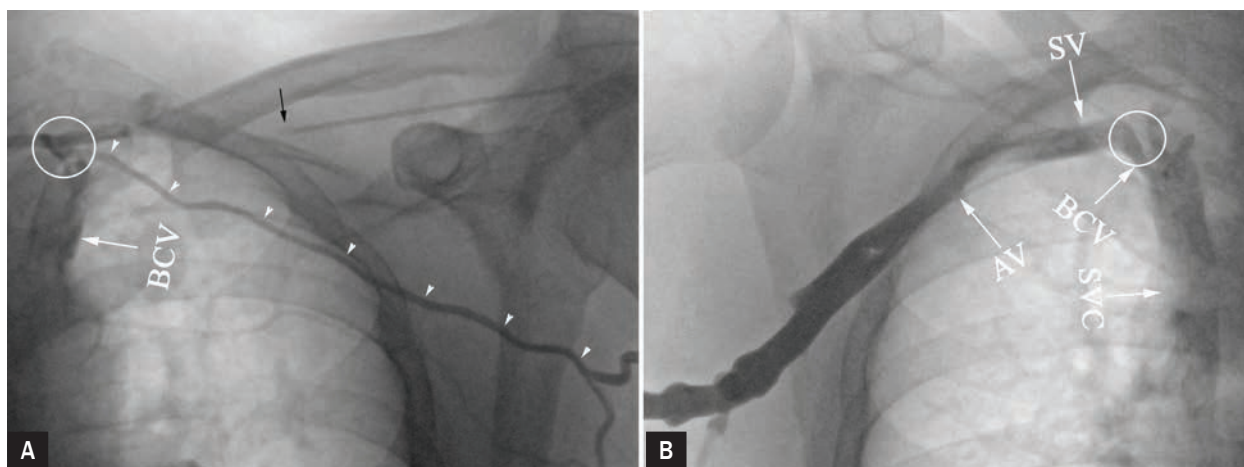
Contrast-enhanced radiographic images showing the morphometry and topography of the veins of both clavipectoral triangles (the left one in panel A and the right one in panel B) in the presented 59-year-old man, and their relationship to the bone structures of the chest. Both venography assessments were performed in posteroanterior (PA) views with the contrast agent administered through a cubital fossa vein. The differentiating characteristics of the drainage sites for the superficial vein (panel A) and the subclavian vein (SV) (panel B) have been marked with circles; namely, the circle in panel A marks the drainage site into a larger vein, which is not the left brachiocephalic vein (BCV), whereas the circle in panel B marks the drainage point of the right SV into the right BCV: A. The left side of the chest. An ineffective attempt at subclavian/axillary vein puncture under venographic guidance; the superficial vein (white arrowheads); the needle from the cardiac lead placement kit (black arrow); B. The right side of the chest. Contrast flow through the patent, lead-carrying veins: the axillary vein (AV) → subclavian vein (SV) → brachiocephalic vein (BCV) → superior vena cava (SVC)
